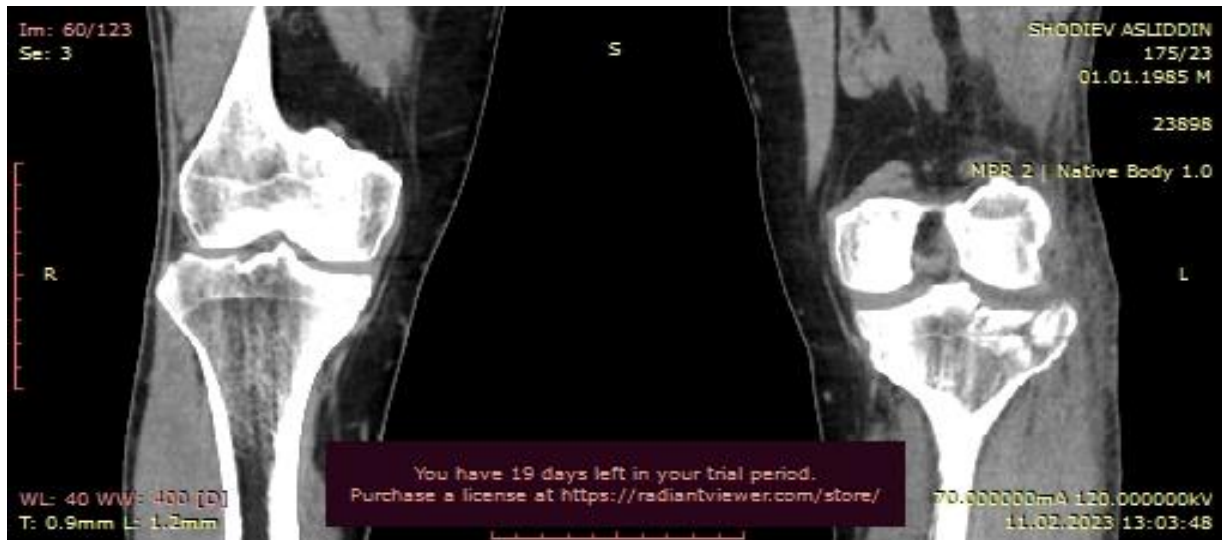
MRI image of a patient with a diagnosis of fracture and displacement of the outer tubercle of the left tibia, partial tear of the anterior horn of the lateral meniscus (patient D. 37 years old, (case history #8514)
